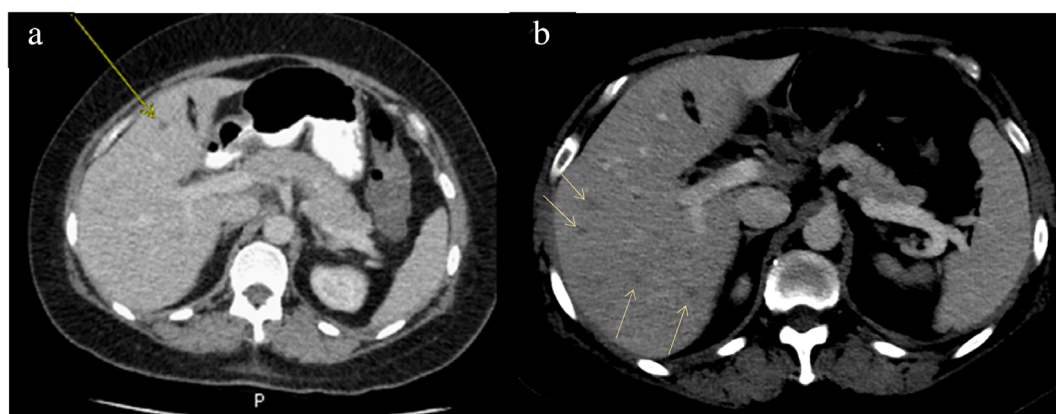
Initial computed tomography (CT) (a) with a nonspecific 5 mm low-density liver lesion. Subsequent CT (b) showing numerous small low-density liver lesions suspicious for a metastatic disease in the liver.
